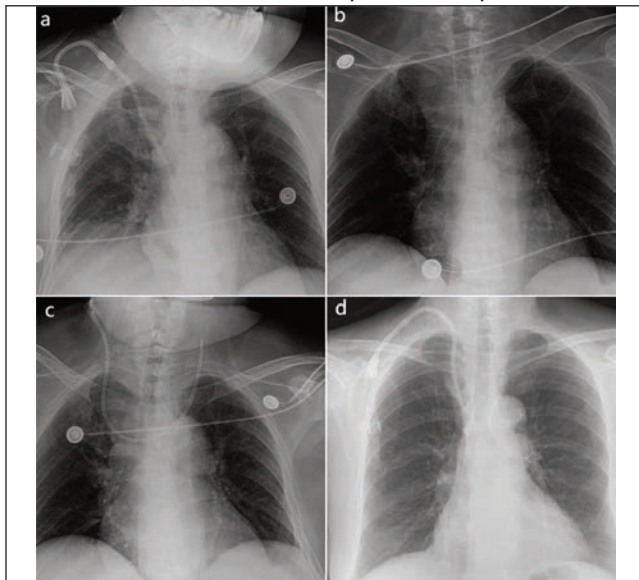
Chest X-ray shows: (a) A permanent haemodialysis catheter was placed into the superior vena cava via the right internal jugular vein; (b) A central venous catheter was peripherally inserted for treatment through the left subclavian vein; (c) A temporary haemodialysis catheter misplaced into the left internal jugular vein via the right internal jugular vein; (d) A cuffed haemodialysis catheter was placed into her right internal jugular vein after endovascular treatment.
